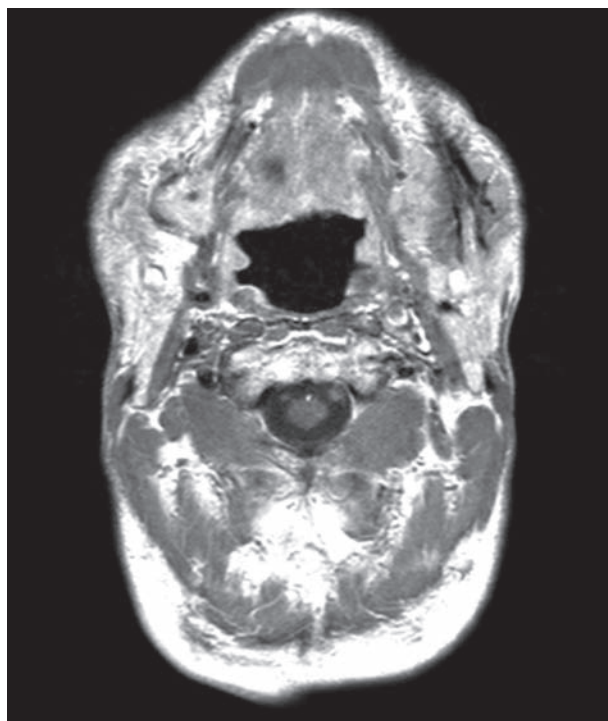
MR T1-weighted axial image of the basal tongue shows a slight hypointensity of the signal in the right basal tongue according to the site indicated by PET/CT
